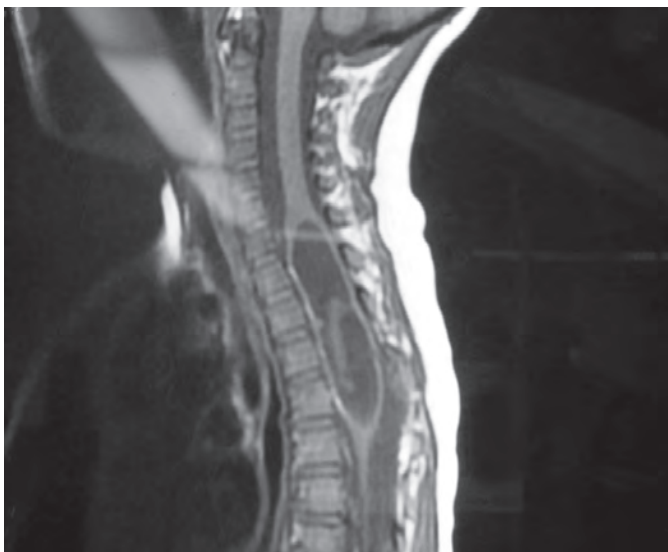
MRI of the upper dorsal spine showing an intramedullary astrocytoma
